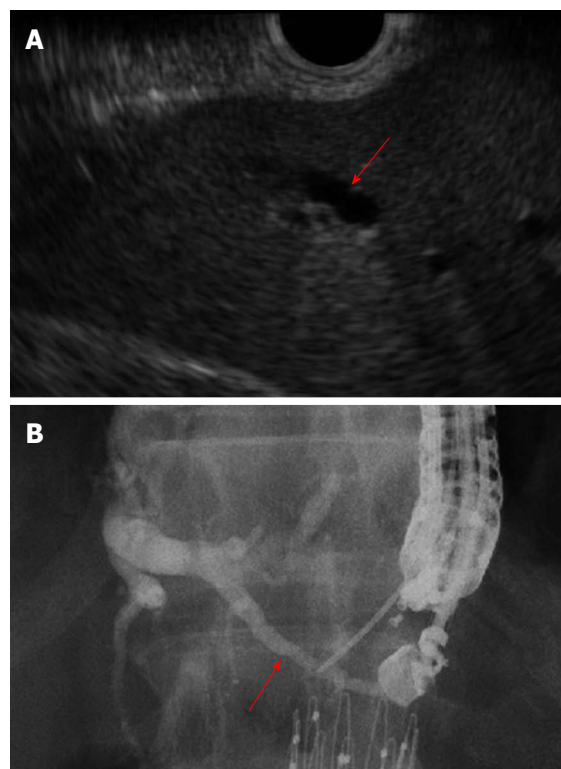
Dislocation of endoscopic ultrasound-guided hepaticogastrostomy metallic stent. (A) EUS-HGS was performed for gastric cancer patient. (B) Because of tumor growth, dislocation of EUS-HGS metallic stent was seen (arrow). EUS-HGS: Endoscopic ultrasound-guided hepaticogastrostomy.
